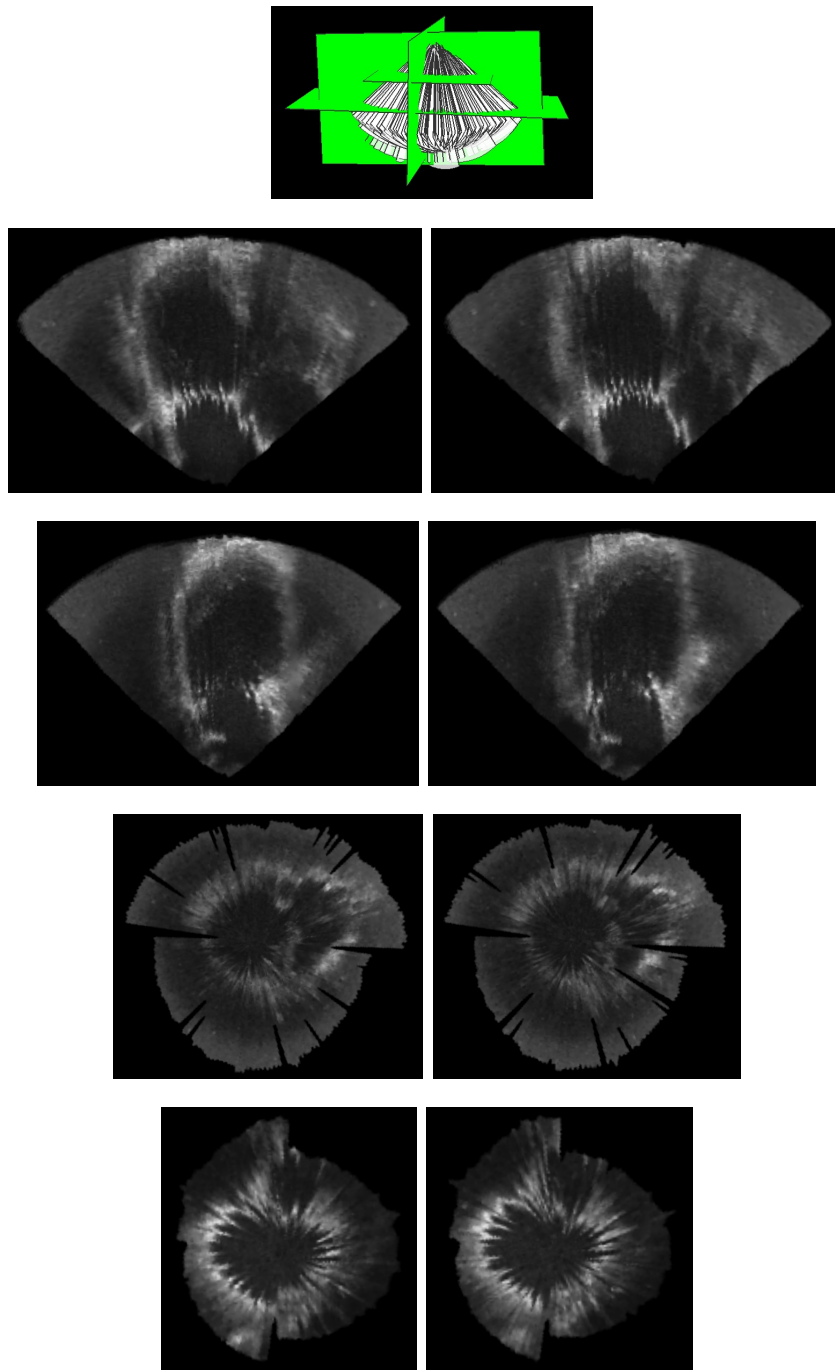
Example clinical 4D ultrasound reconstruction at the 15% (left) and 65% (right) R-R intervals, acquired using the TEE probe with a rotational acquisition before left lung collapse. (Patient 1: US depth setting = 15 cm,  $s_{in} = 0.43$  mm,  $s_{out} = 0.81$  mm, output dimensions =  $433 \times 354 \times 478$ ,  $HR_{exp} = 48$  bpm,  $\%dev_{HR} = 10\%$ ,  $N = 20$ ,  $P = \{3, 13\}$ ).
